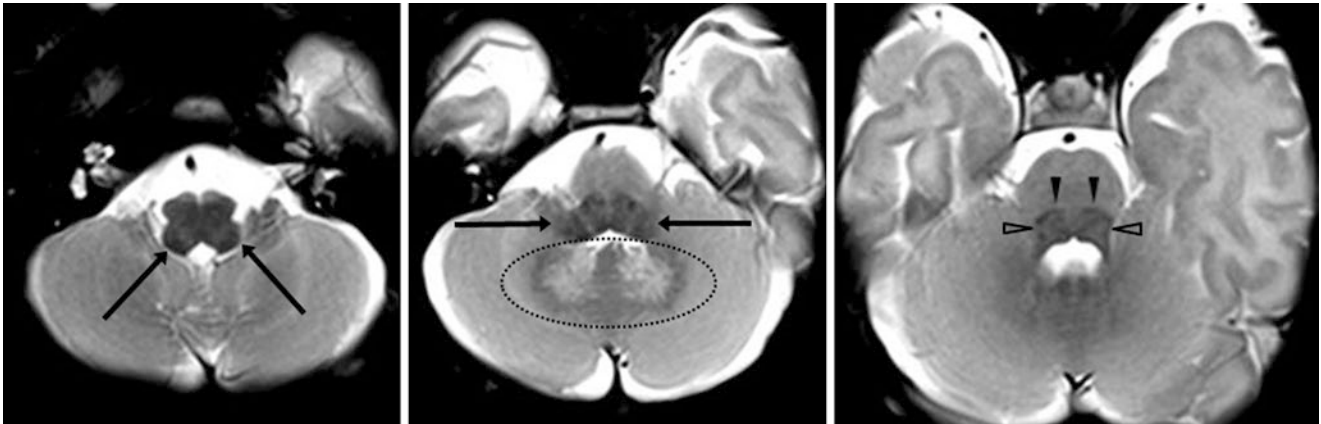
A 1-day-old term neonate had a normal 3T MRI with SE T2WIs, which demonstrate the ICP (*long arrows*) at two levels. Also, note the lateral lemnisci (LL) (*open arrowheads*) and medial lemnisci
